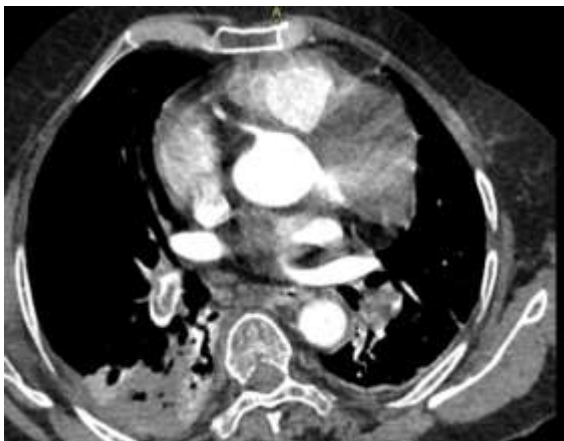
Contrast-enhanced computed tomography pulmonary angiography demonstrates filling defects extending into the lower lobe segmental branches of the pulmonary arteries.
